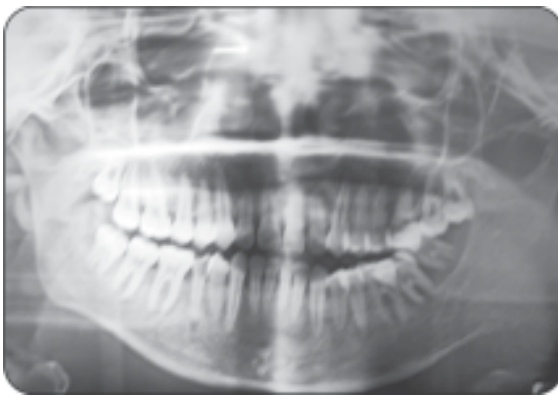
Radiograph of Warthin's tumor
